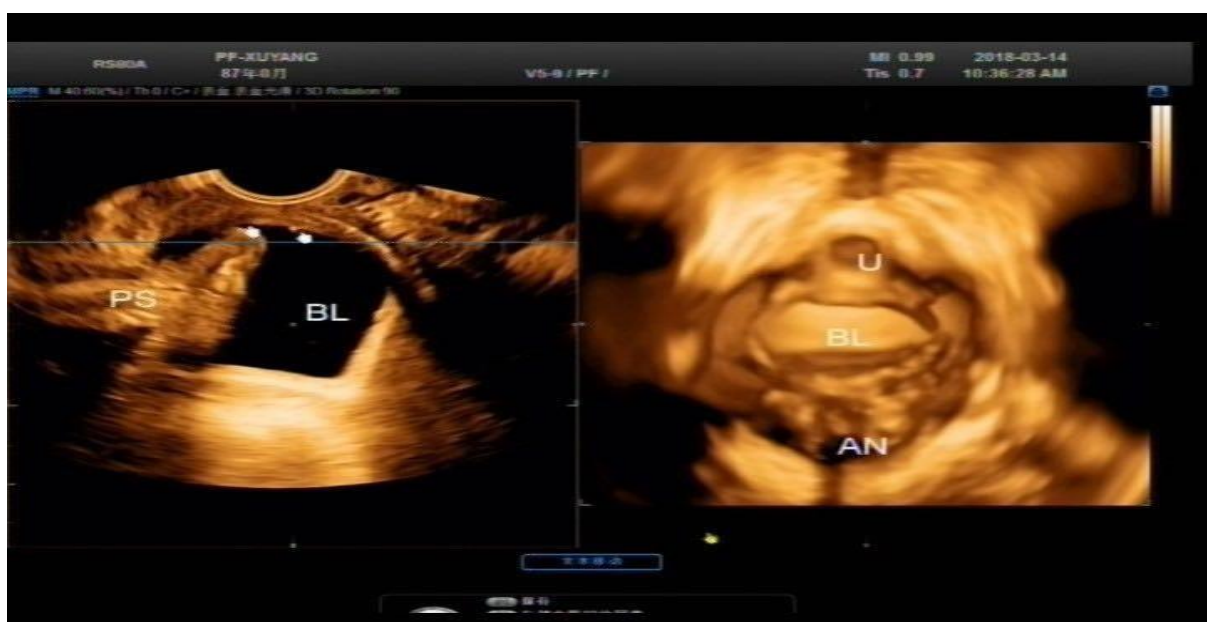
Pelvic Floor Ultrasonography Image
